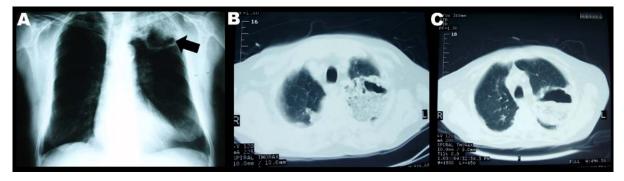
A: Posteroanterior chest radiograph shows left upper lobe consolidation and a cavitary opacity in the left upper lobe, B. Chest CT revealing caseous necrosis and ground glass opacities in the left upper lobe, C. Chest CT revealing a cavity with irregular borders and air-fluid levels, secondary to caseous necrosis, surrounded by thick outer wall
